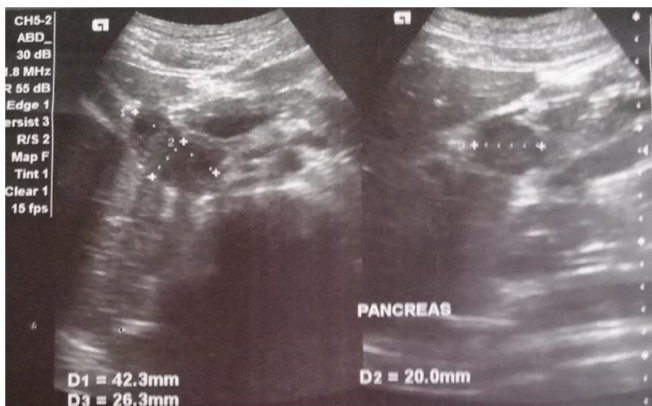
Whole abdominal ultrasound showed a hypoechoic solid focus in the peri-pancreatic region
